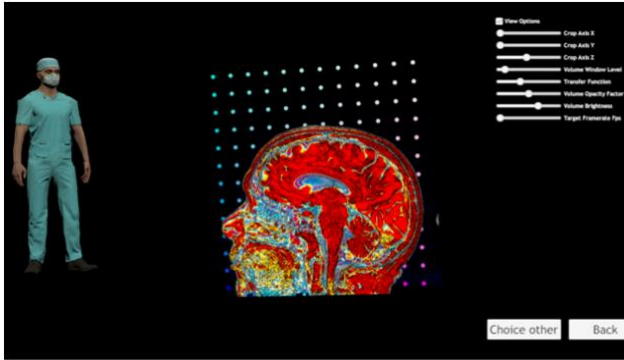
Visualization and processing of an MRI 3D VR model with the Visualization Toolkit.
